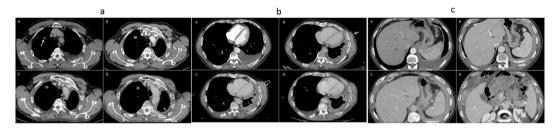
a) Slow progression of pleural and pulmonary disease. A) Baseline CT demonstrates a small left sided pleural effusion with a subtle nodular pleural disease posteriorly (open arrow). A pulmonary metastasis in the right upper lobe (closed arrow) measures 10mm in maximal diameter at baseline. B, C & D) CT studies at 46 months, 54 months and 65 months respectively post baseline demonstrating a slow interval progression. The pleural disease is circumferential but shows very little change from 46 to 65 months. The right lobe metastasis measures 13mm on all three studies. Fig. 2b) New site of disease developed during treatment in left chest wall at site of previous biopsy. A) No disease seen in left chest wall at baseline CT. B) 31 months CT study demonstrates subtle soft tissue nodule (closed arrow) in left chest wall but patient asymptomatic from this site. C) 50 months CT study demonstrates marked enlargement in the left chest wall mass (open arrow) which is infiltrative within the left serratus anterior muscle. The mass is now symptomatic with new chest wall pain attributed to this disease. D) 65 months CT study demonstrates slight reduction in bulk of left chest wall disease post-radiotherapy. Fig. 2c) New site of disease developed during treatment within the peritoneal cavity. a) No peritoneal disease at baseline. b) New subtle haziness of peritoneum (closed arrow) at 46 months. c) Progression of the peritoneal haziness in the right subphrenic space at 50 months with a small amount perisplenic ascetic fluid (asterix). C) 65 months CT study shows thickened peritoneal metastasis in right subphrenic space with an increase in ascitic fluid.
